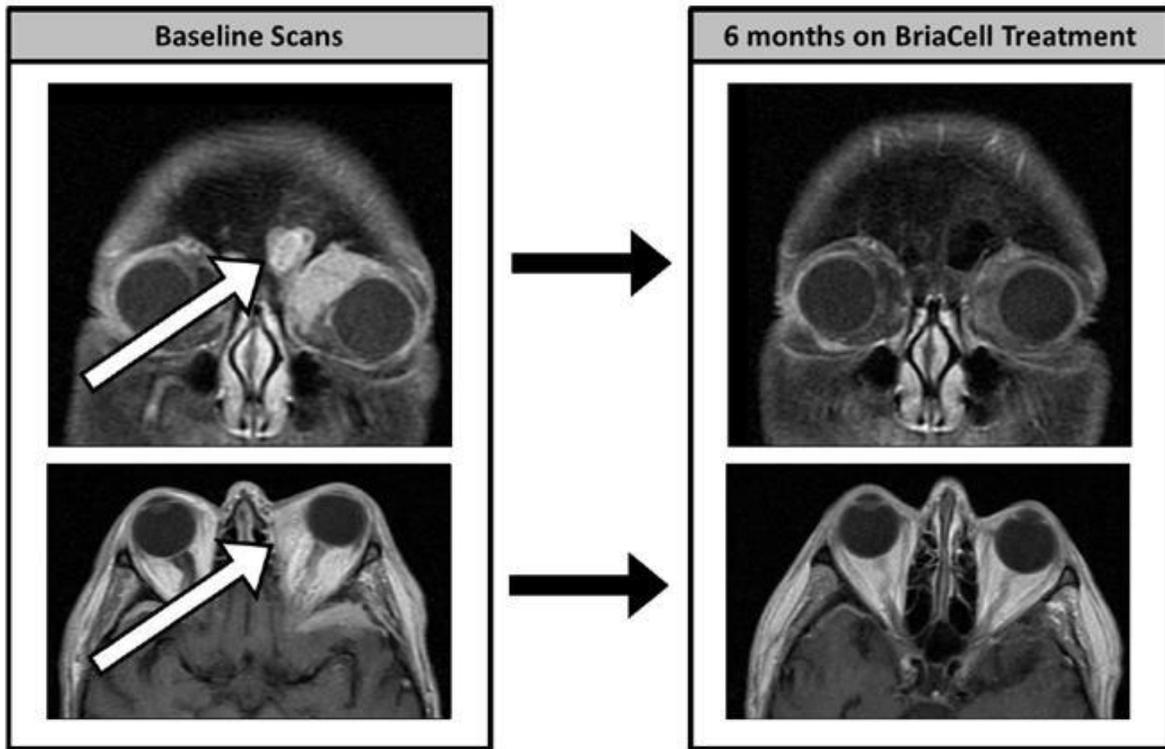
The figure shows MRI scans of the top responder patient. The arrows on the images (baseline scans) show the location of the orbital tumors. As shown on the images on the right hand side, the tumors were eliminated following 6 months of treatment with the Bria-IMT combination regimen.
